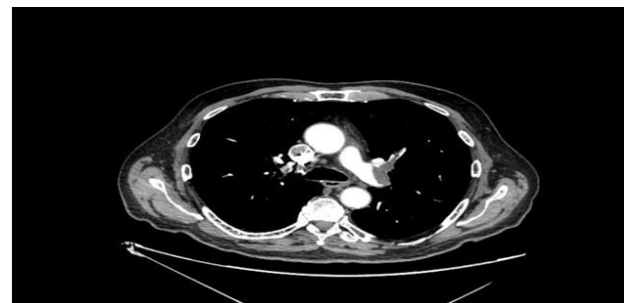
Cross-sectional CT angiography
